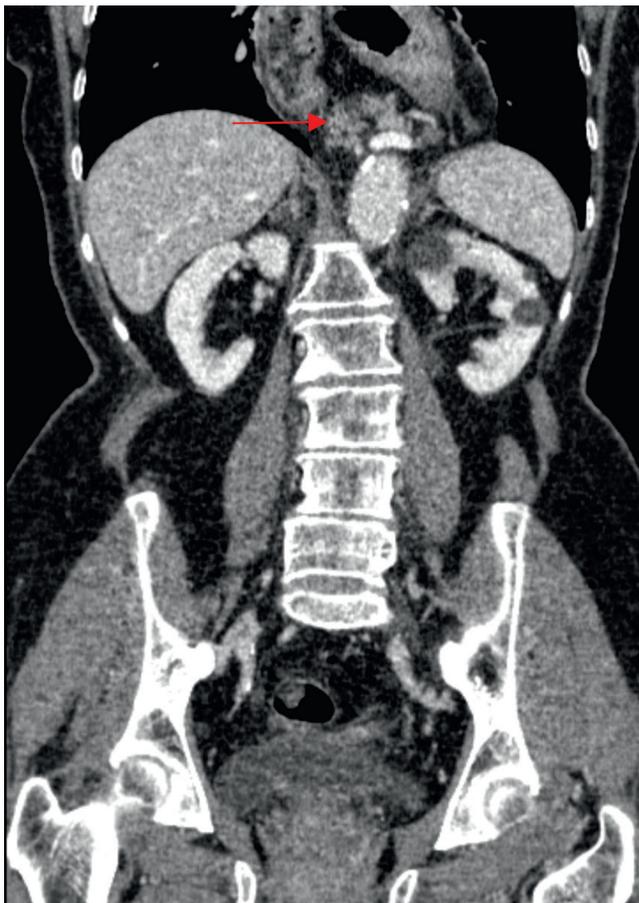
CT scan showing a paraesophageal hernia involving the pancreatic body (red arrow) – coronal view.
